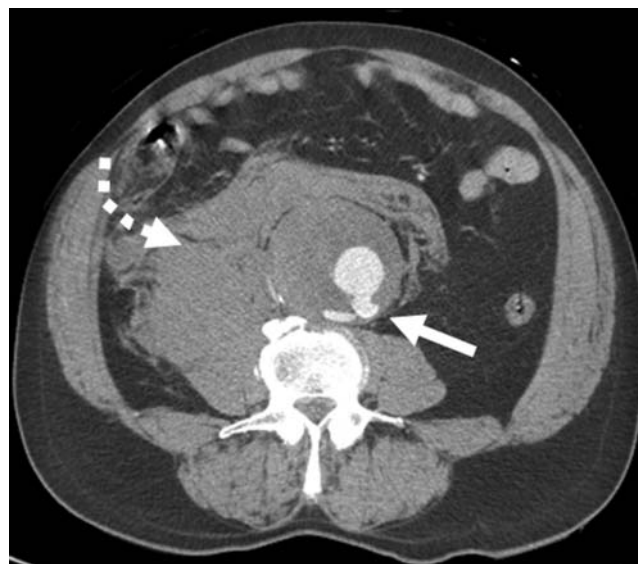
Ruptured abdominal aortic aneurysm. Computed tomographic angiography of the abdominal aorta demonstrating a large right-sided retroperitoneal hematoma (broken arrow) and a 7.9 cm abdominal aortic aneurysm (solid arrow).
